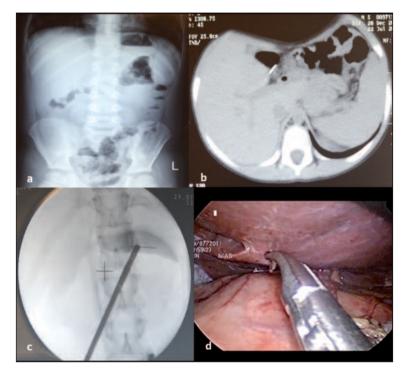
1a. Plain abdominal X-ray of Case 1 demonstrates needle, 1b. Computerized tomography of Case 1 demonstrates foreign body located extraluminally at posteroinferior of the liver, 1c. Fluoroscopic view of Case 2 during laparoscopy 1d. Laparoscopic view of the needle buried in the liver in Case 2. (See color figure at http://www.turkiyeklinikleri.com/journal/pediatri-dergisi/1300-0381/)
